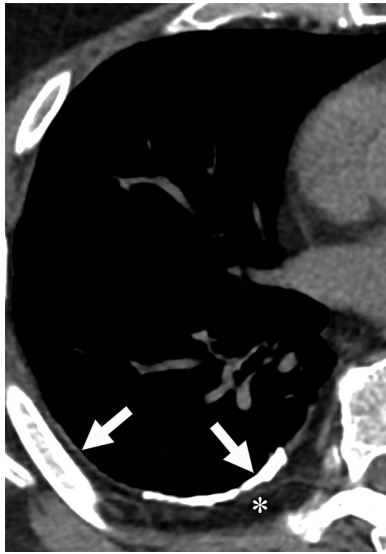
Pleural fibrosis secondary to prior hemothorax. Axial CT image shows pleural plaques with associated thick coarse calcifications (arrows). Note the thickened extrapleural adipose tissue (*).
